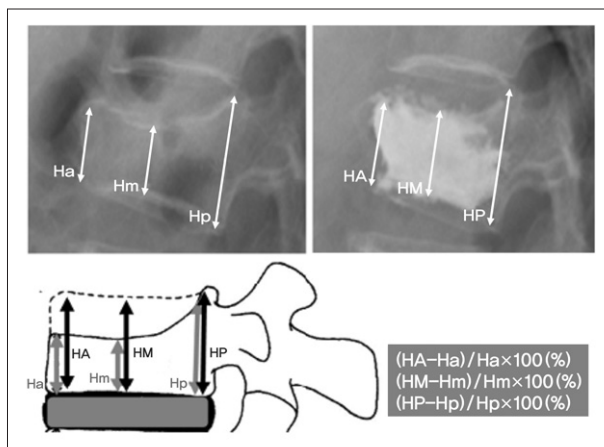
Preoperative and postoperative radiographs obtained to quantify the percentage height gain (anterior, middle, and posterior fractured vertebral body heights). (Ha, Hm, Hp : preoperative anterior, middle, and posterior vertebral height, respectively HA, HM, HP : postoperative anterior, middle, and posterior vertebral height, respectively).
